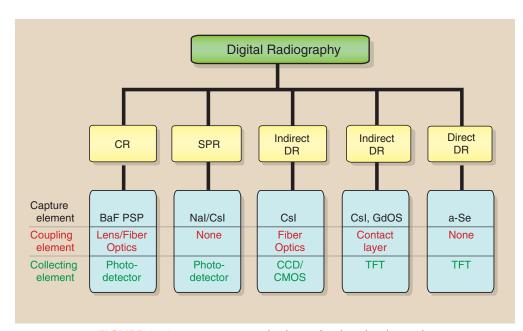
An organizational scheme for digital radiography.
